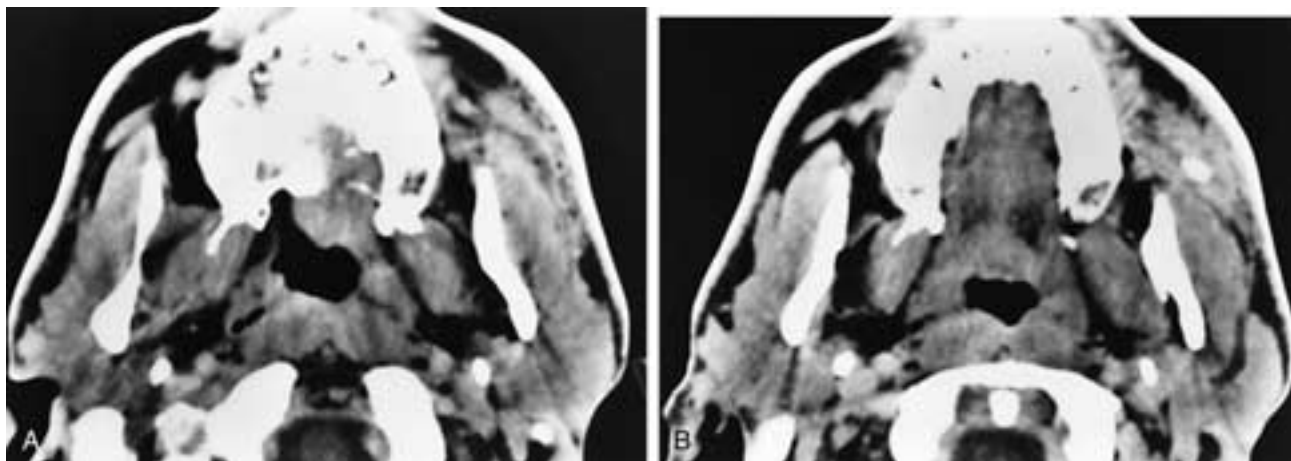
Axial contrast-enhanced CT scans (A, B) show increased attenuation in the left subcutaneous soft tissues overlying the region of the left part of Stensen's duct. There is also thickening of the left masseter muscle. In B, a more caudal scan, there is a small calculus in Stensen's duct with surrounding inflammatory changes. The routine plain films on this patient were normal. This patient had sialodochitis, sialolithiasis, and cellulitis.
